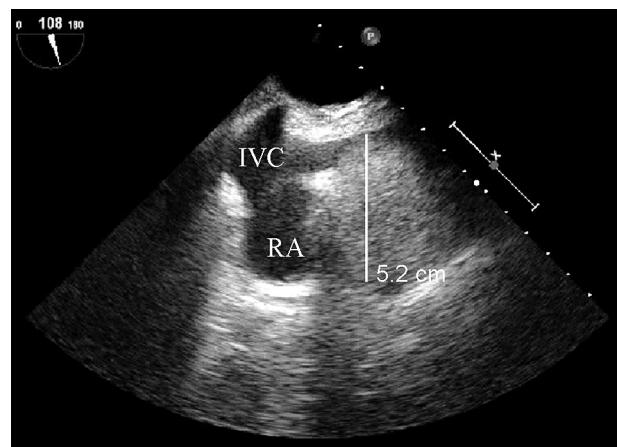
Intraoperative transoesophageal echocardiography showed a mass attached to the right atrial wall measuring 5.2 cm. The inferior vena cava was free of compression
